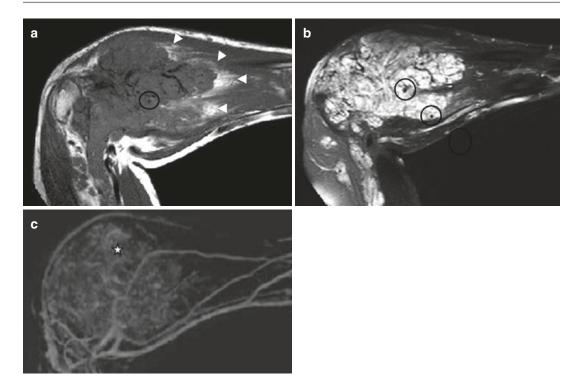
Intramuscular venous malformation of the upper extremity. (a) Sagittal T1-weighted MR image. (b) Sagittal T2-weighted image with fat saturation. (c) Maximum intensity projection (MIP) after 3D contrastenhanced MR angiography, late venous phase. (a) T1-weighted image shows an intramuscular and extensive lesion which involves the forearm muscles and elbow joint, surrounded by fat component (*arrowheads*). (b) The
